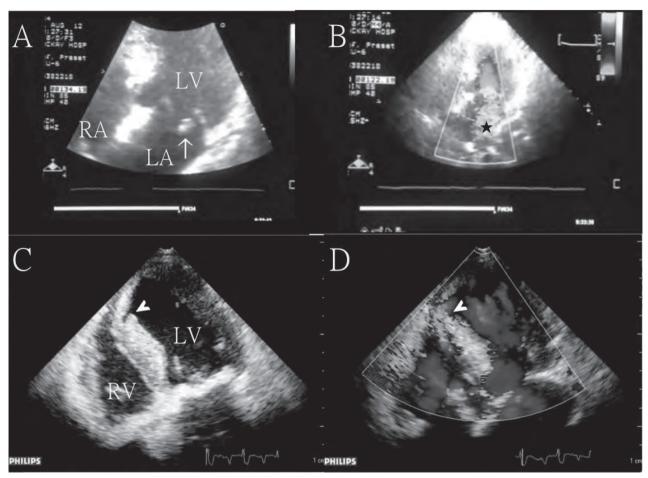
Echocardiographic images of mechanical complications in acute myocardial infarction.
